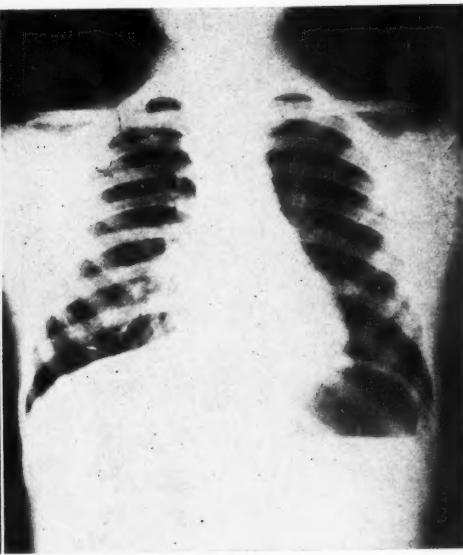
The mediastinal tumor is entirely retrogressed after x-ray treatment.
